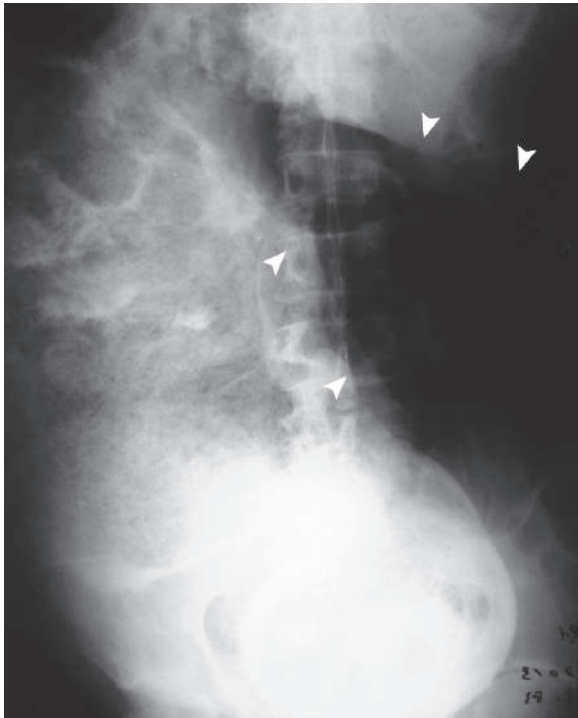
Plain abdominal radiograph shows toxic megacolon (arrowheads)
